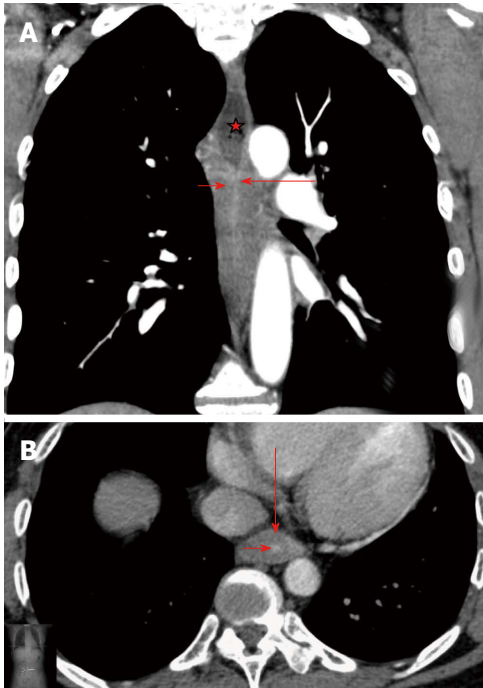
Corrosive esophageal stricture. A: Multidetector computed tomography (MDCT). Arterial phase. Coronal reconstruction. Concentric esophageal wall thickening of the corrosive stricture, which has a homogeneous structure (short arrow). The mucosa is traceable as a thin hyperintense line in the centre of thickened walls that was caused by fibrotic changes (long arrow). Conically shaped suprastenotic dilatation (star) with smooth upper boundaries of the stricture; B: MDCT. Arterial phase. Axial CT scan. Target sign - thickening of saved esophageal mucosa (short arrow) in the centre of fibrotically changed submucosal, muscular layers and adventitia of esophageal walls (long arrow).
